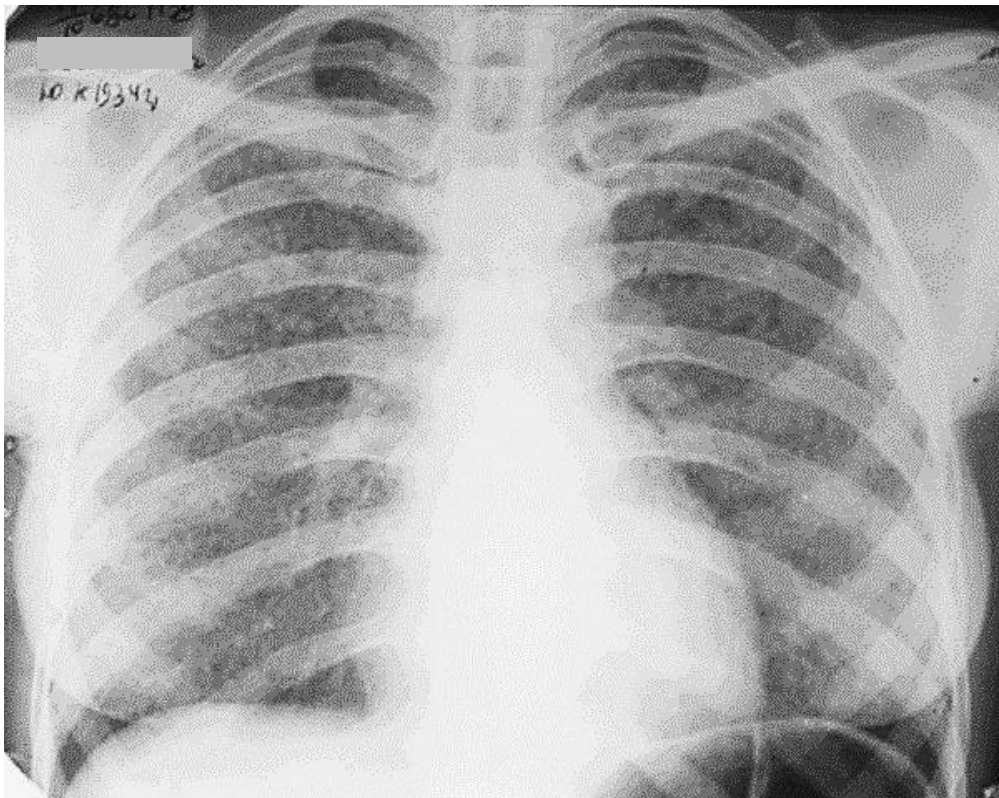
The frontal chest radiograph. There is microfocal diffusive dissemination (miliary patterns) on the both sides along all pulmonary fields. Hematogenous disseminated (miliary) tuberculosis
